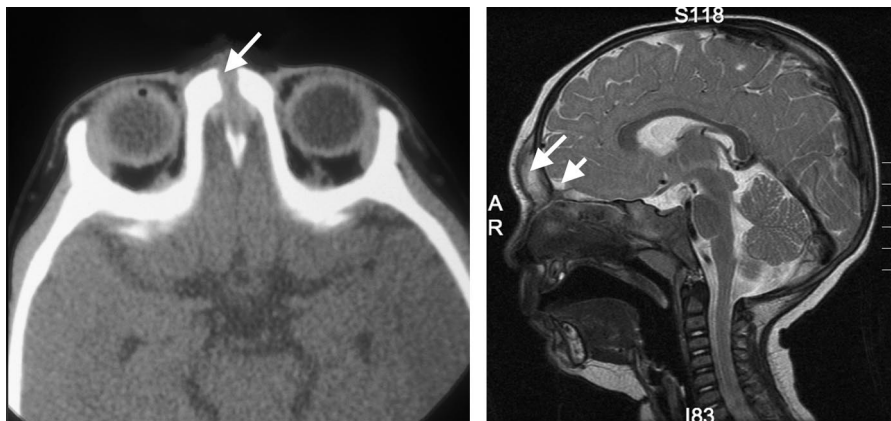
Classic appearance of nasal dermoid sinus cyst with intracranial extension. CT (left) shows a defect in the nasal bone (arrow) in the midline and bifid crista galli, while MRI (right) shows an enhancing lesion in the anterior cranial fossa and subcutaneously (arrows). T2 sagittal image.
